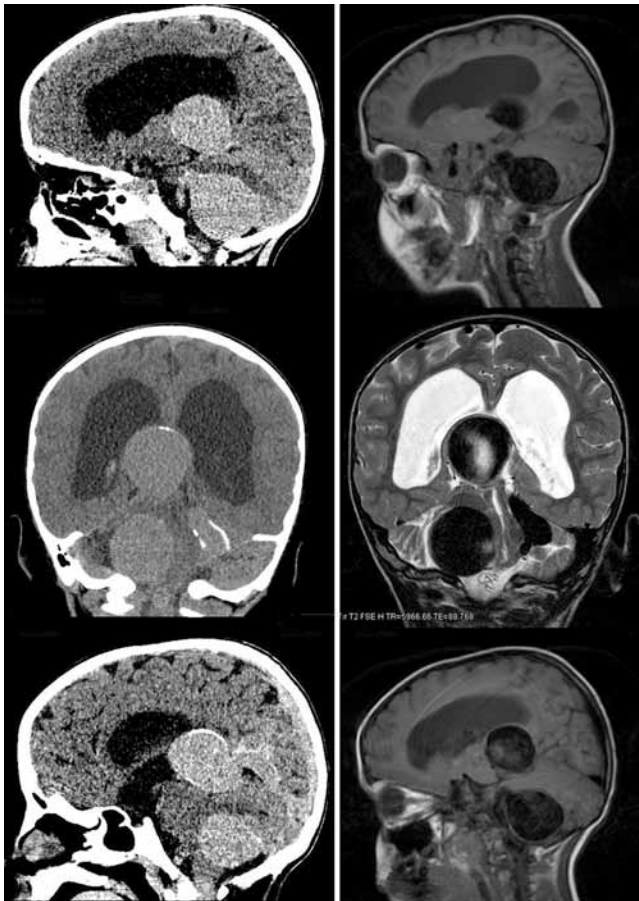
Case 1. Preoperative CT scans (left) and MR images (right) showing the large venous varices displacing the brainstem and compressing the aqueduct, resulting in obstructive hydrocephalus.
